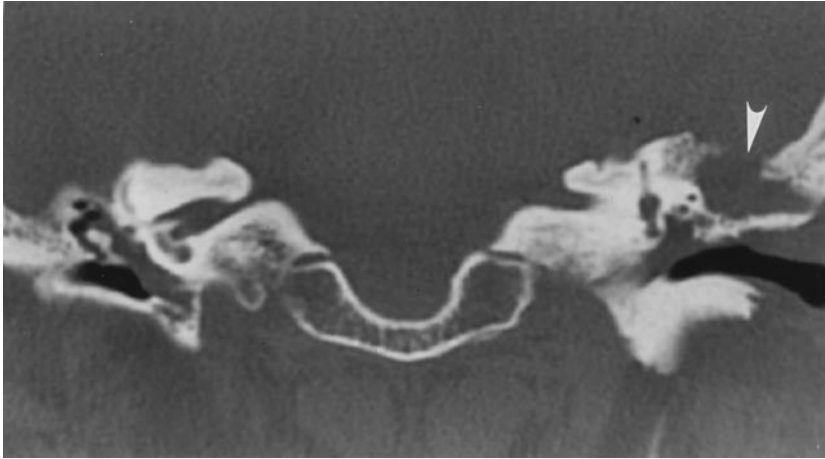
Coronal CT scan of temporal bones in a patient with recurrent meningitis. The tegmen defect (*arrow*) was filled with an arachnoid granulation adherent to the temporal lobe
